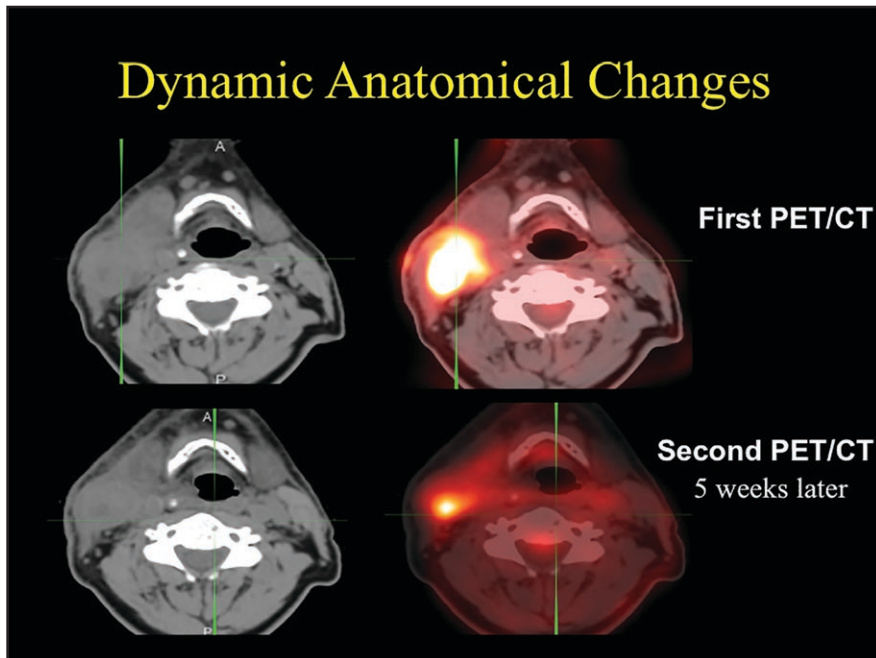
The top panel is a cross-sectional PET/CT image, acquired 1 week prior to radiotherapy. The patient had enlarged neck lymph nodes on the left side, as shown in both CT and PET images. The bottom panel is a cross-sectional second PET/CT, acquired 4 weeks after IMRT, showing significant tumor shrinkage in response to IMRT treatment.
